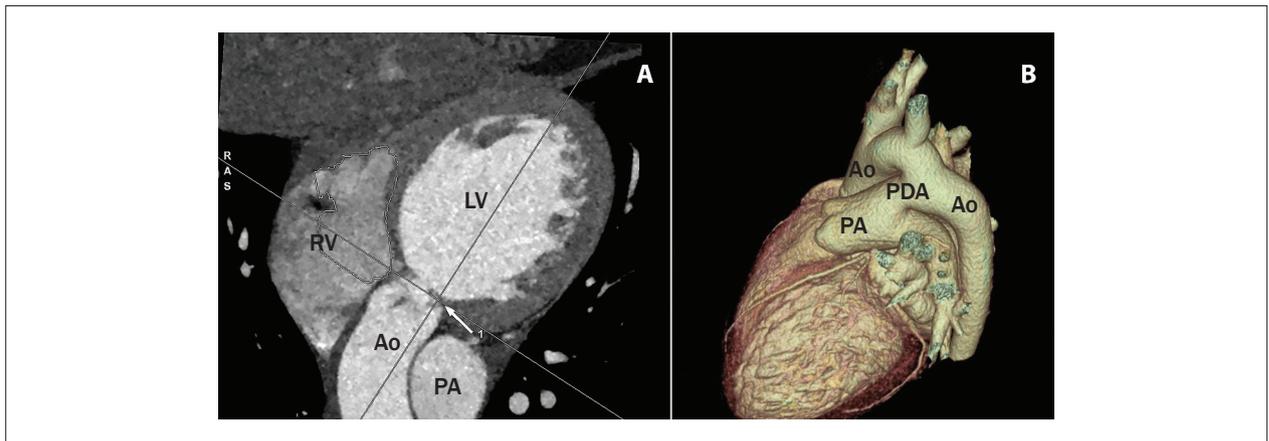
Computed tomography angiography findings. (A) White arrow showing subvalvular aortic stenosis, membranous type. (B) Patent ductus arteriosus type A (conical ductus) arising after the origin of left subclavian artery and running from the descending aorta to the pulmonary trunk. Ao: Aorta; LV: left ventricle; PA: pulmonary artery; PDA: patent ductus arteriosus; RV: right ventricle.
